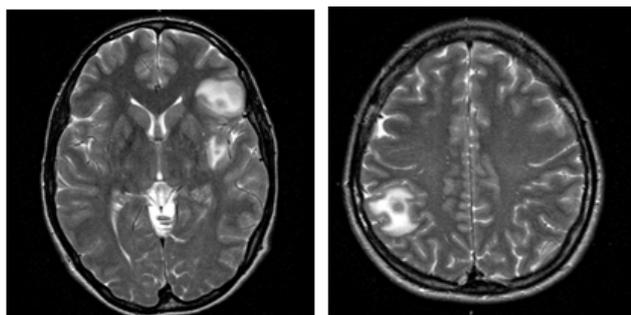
MRI brain (Flair) Showing multiple supratentorial ring enhancing lesions with surrounding vasogenic edema
